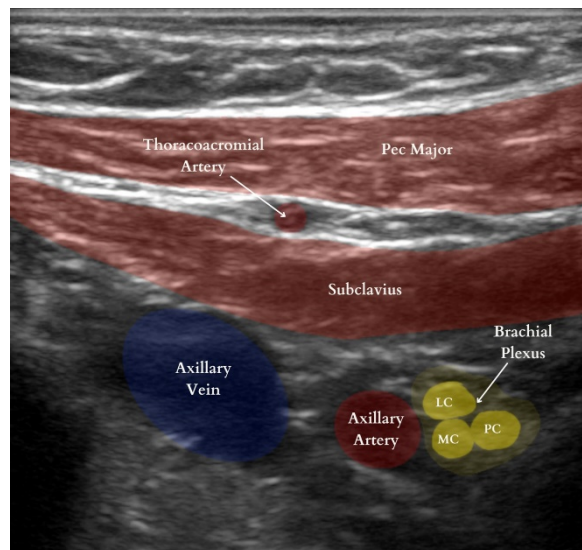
Sonographic image of costo-clavicular space
